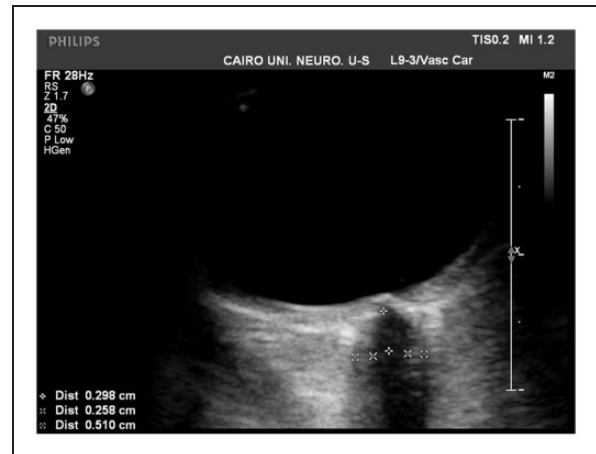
Sonographic measurement of the optic nerve sheath diameter, calculated by the distance between the two cursors measured 3 mm posterior to the globe.
